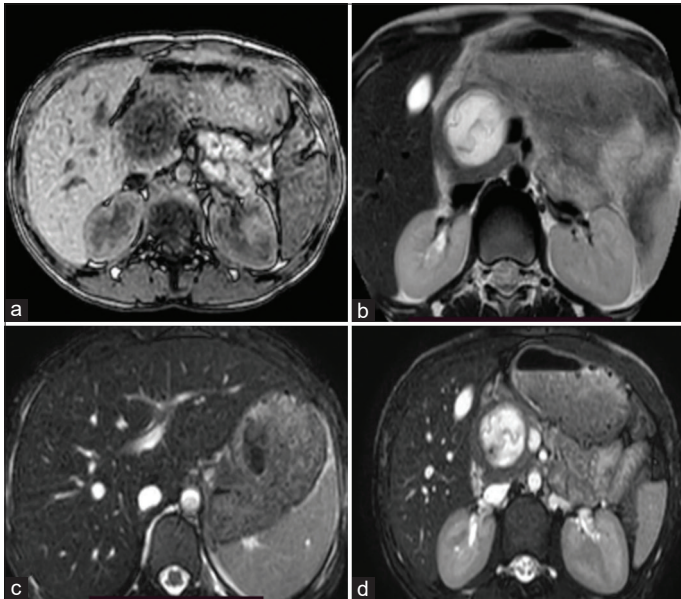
Magnetic resonance imaging of the pancreatic hydatid cyst. (a) axial T1W; (b) axial T2W, (c and d) axial T2W with fat suppression images showing pancreatic head cyst with internal free-floating membranes, no intrahepatic biliary radical dilatation, no other abdominal cavity cysts
